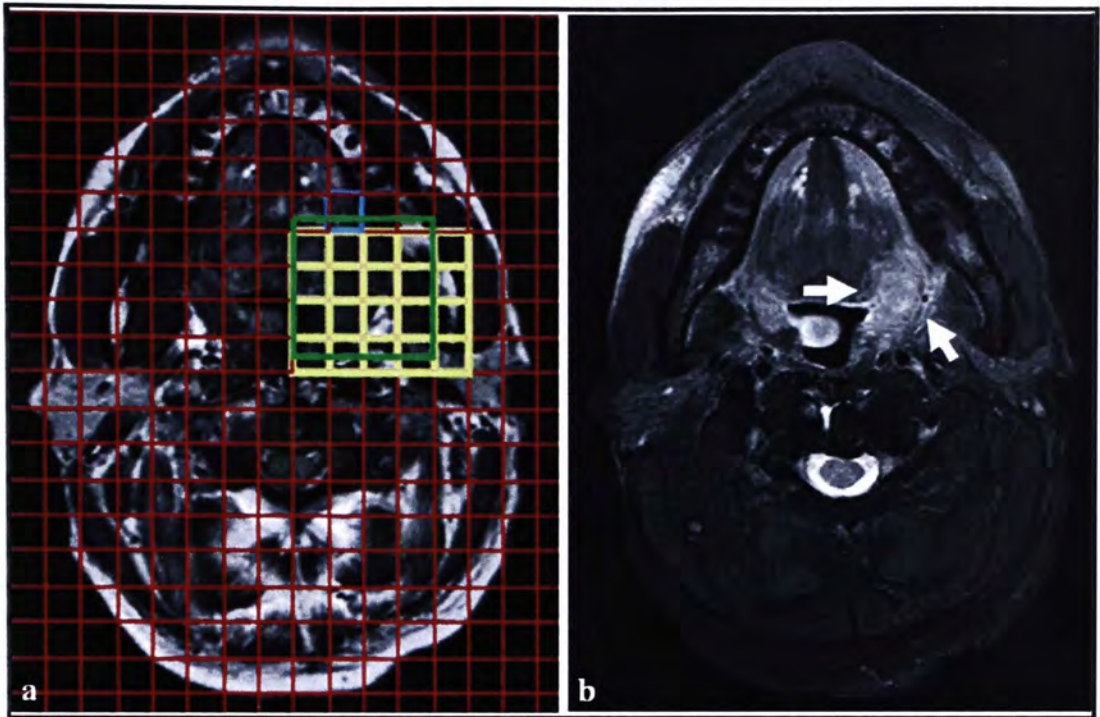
MRI images of a 59-year-old patient with SCC (subject 10).
